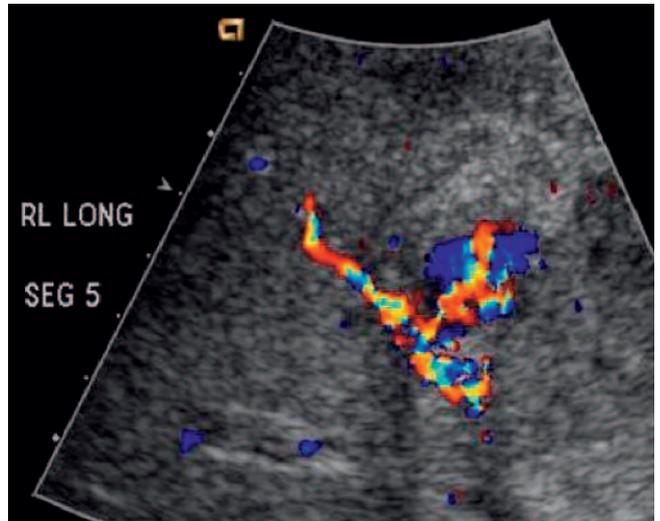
Doppler ultrasound demonstrating pseudoaneurysm of the intra-hepatic portion of the hepatic artery.
